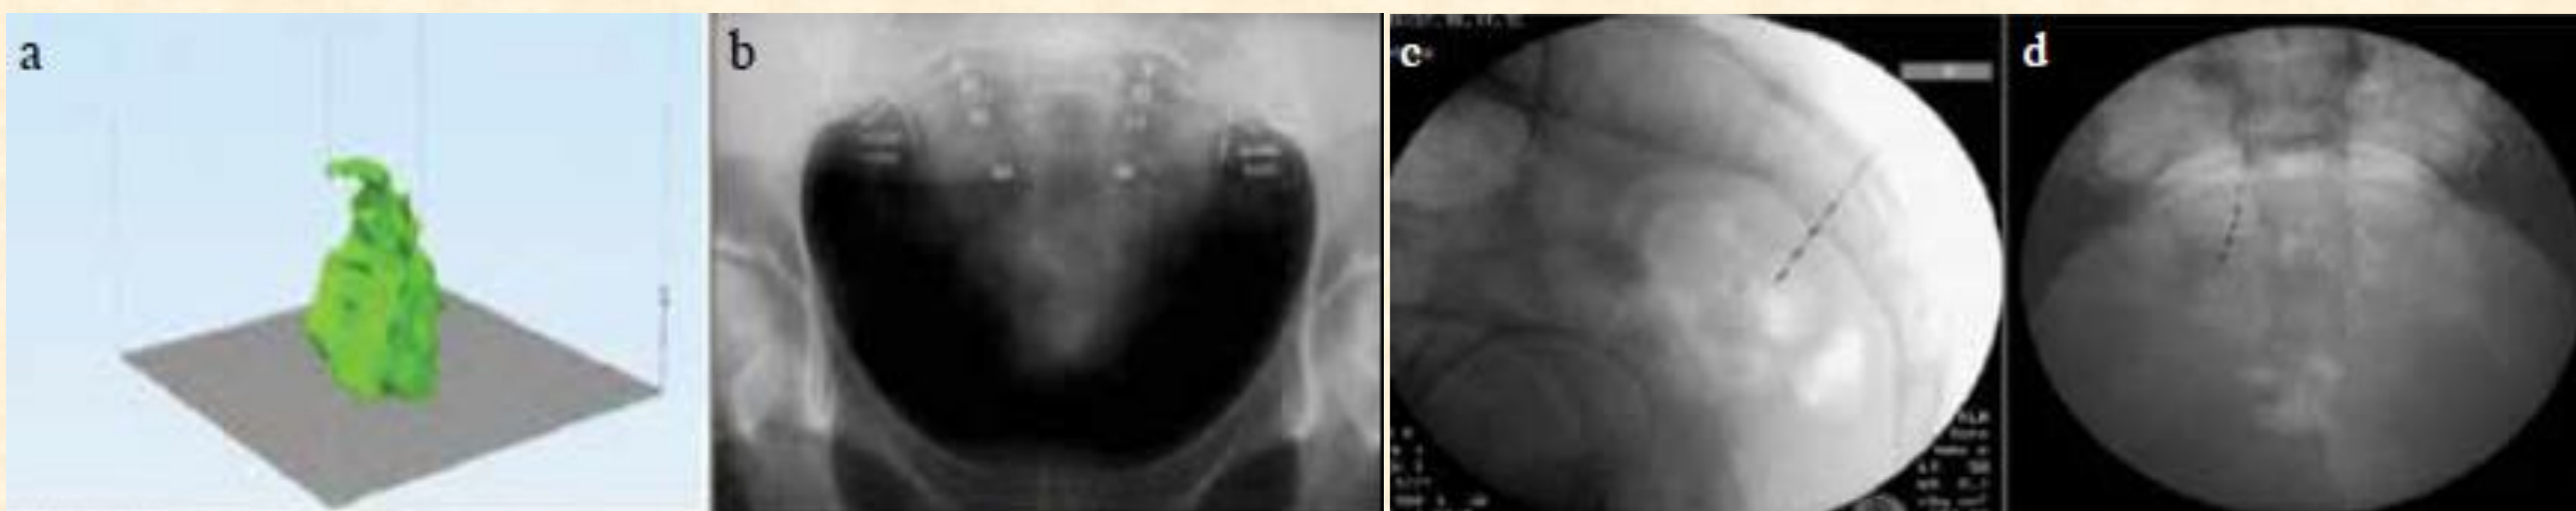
a-d. 3D sacral bone model obtained by the patient's CT images (a). X-ray determination of sacral foramen (b). The electrode placement to S3 foramen (c). Insertion of electrode into S3 foramen (d)
